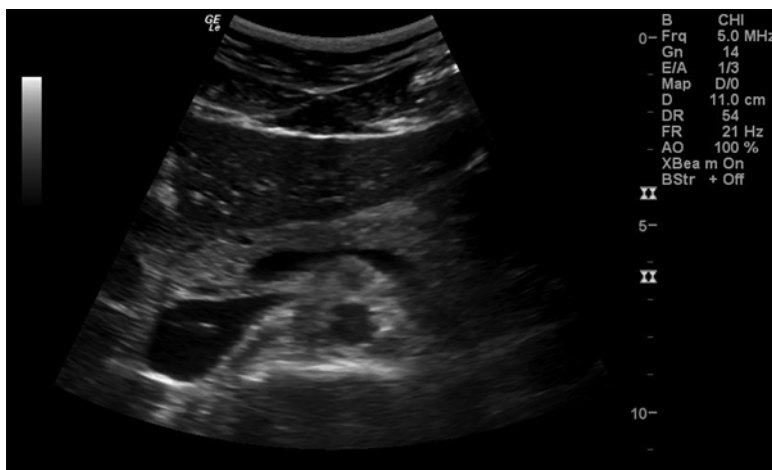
Showing a typical B-mode or 2D ultrasound image
